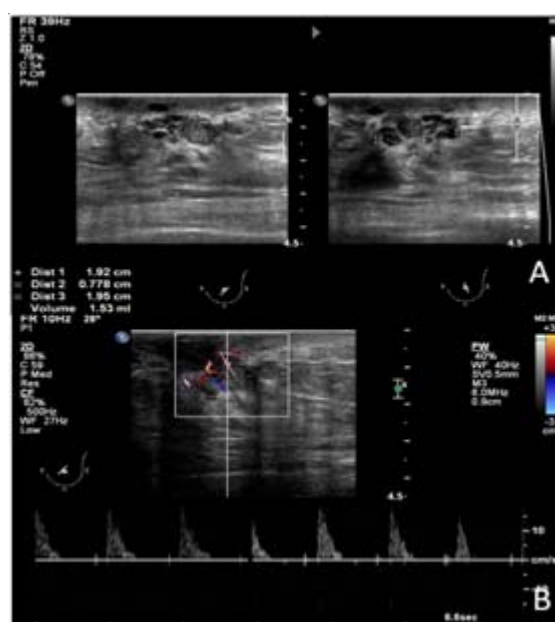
Ultrasonography of the left breast (A) shows an ill-defined irregular hypoechoic mass at the subareolar area with multiple vascular feedings when using a color Doppler technique (B), estimated size about $1.9 \times 0.8 \times 0.9$ cm³ (volume = 1.53 ml). Diffuse skin thickening and subcutaneous edema of the left breast were demonstrated.
